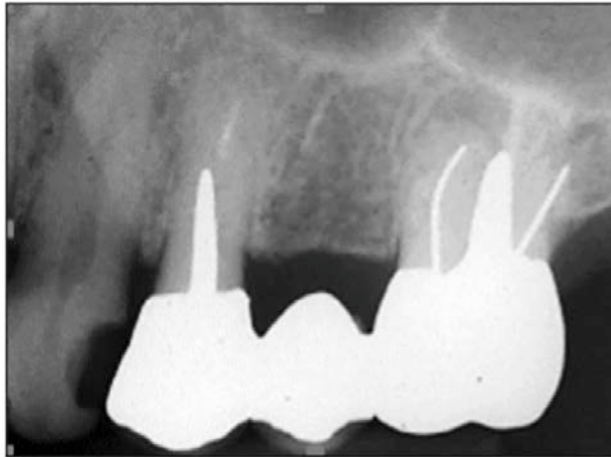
Periapical radiograph of maxillary posterior bone pattern.
